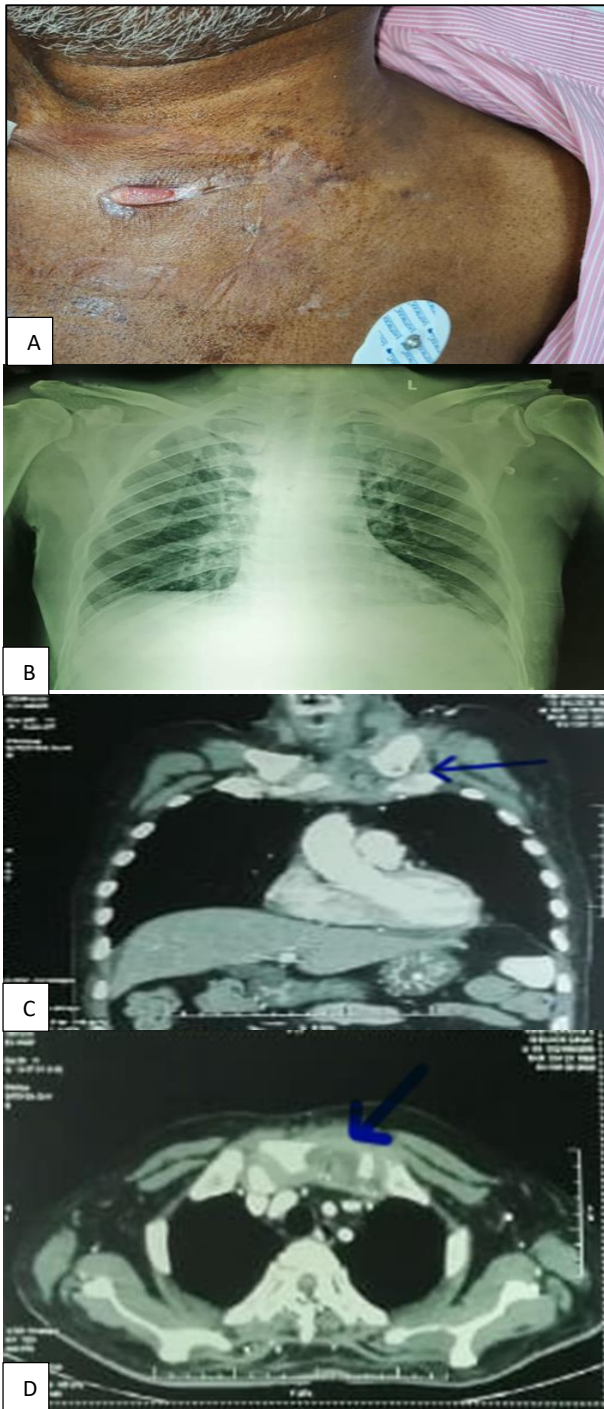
(A-D): Discharging sinus at the time of presentation over medial end of clavicle, presenting radiograph, coronal CT cuts showing erosion of clavicle with pus collection and axial cuts showing clavicle osteomyelitis and bone destruction.
